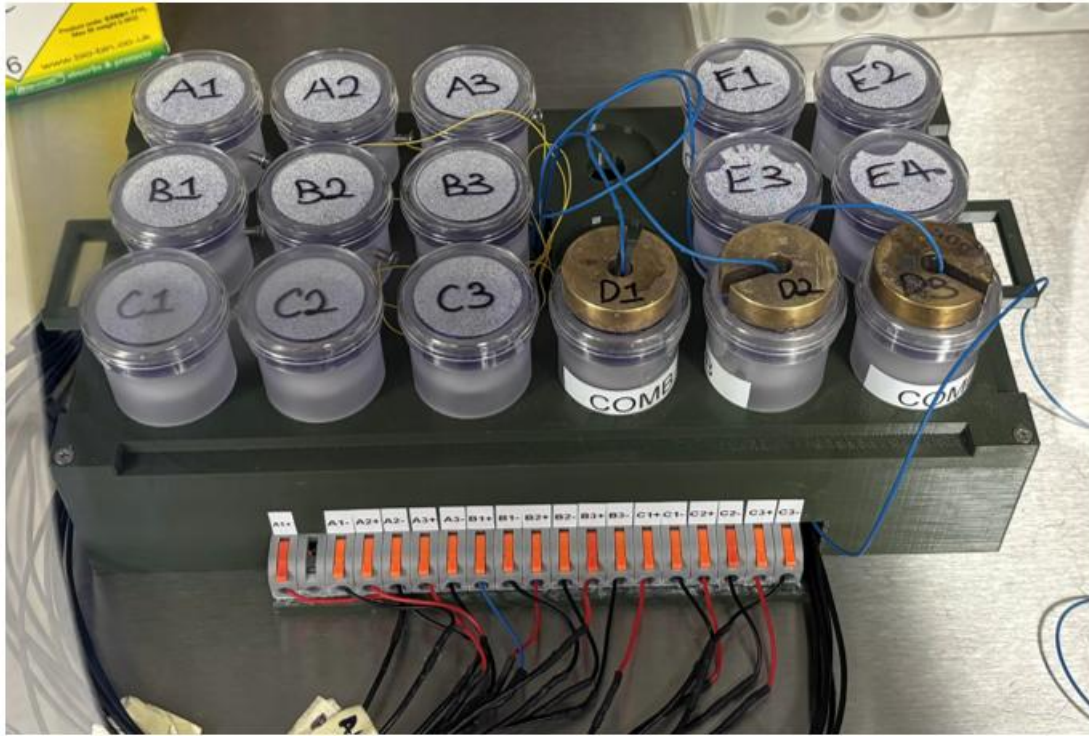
Custom-designed testing rig for delivering ultrasound to osteoblast-seeded implants in bioreactor chambers.
